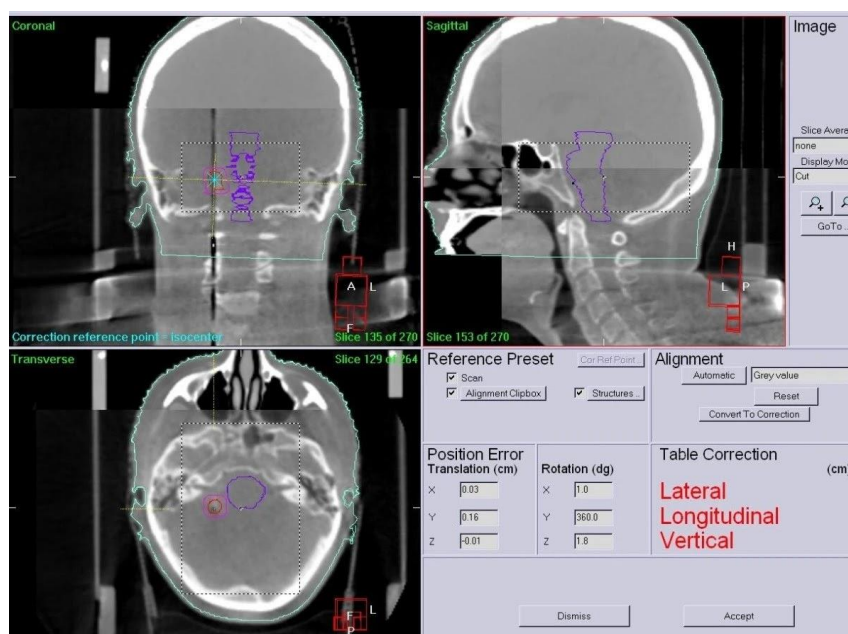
An Example of a CBCT Image of a Patient Treated to the Head and Neck Region (Ingrosso et al.,2012)
